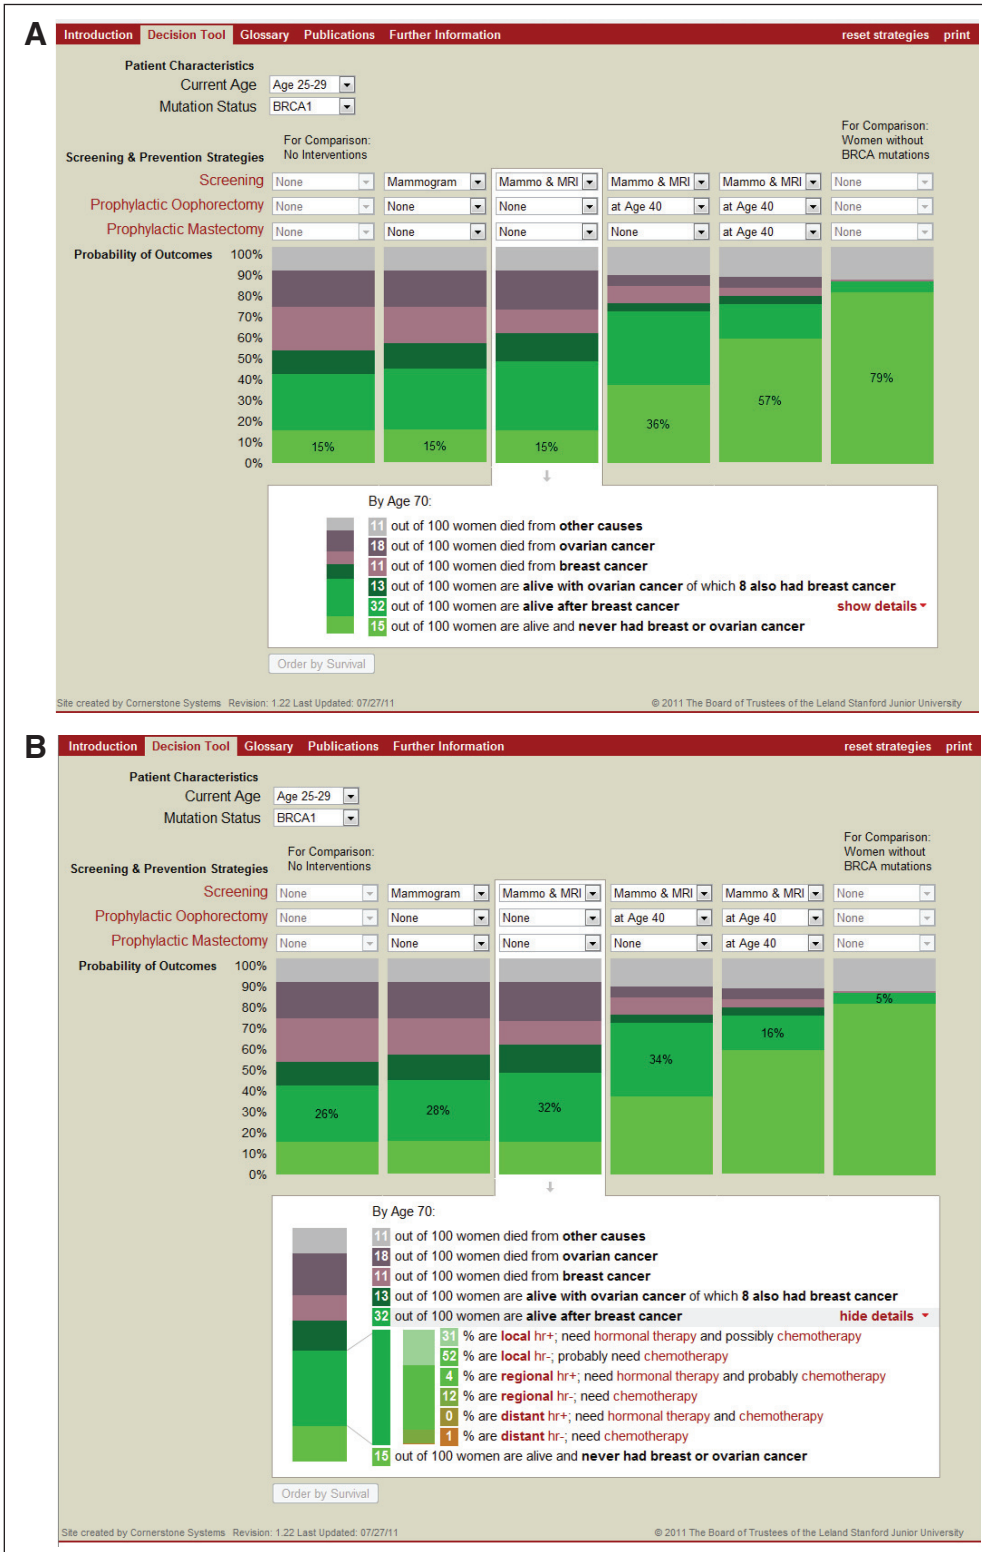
(A) Display screen of online decision tool (brcatool.stanford.edu) comparing user-selected scenarios for cancer risk reduction. Screening options include yearly mammography (Mammo) and/or magnetic resonance imaging (MRI); preventive options include prophylactic mastectomy or salpingo-oophorectomy at various ages. Each bar shows the probability of outcomes by age 70 years under the selected strategy in terms of cancer-free survival (light green), survival after breast cancer (darker green), survival with ovarian cancer (darkest green), and death resulting from breast cancer (pink), ovarian cancer (purple), and other causes (gray). Terms in red font are linked to definitions in the glossary. (B) Expanded display screen of decision tool, showing additional details of each user-selected scenario (vertical bars) in terms of breast cancer stage (local, regional, distant), hormone receptor (hr) expression (negative – or positive +), and recommended systemic therapies according to practice guidelines.
